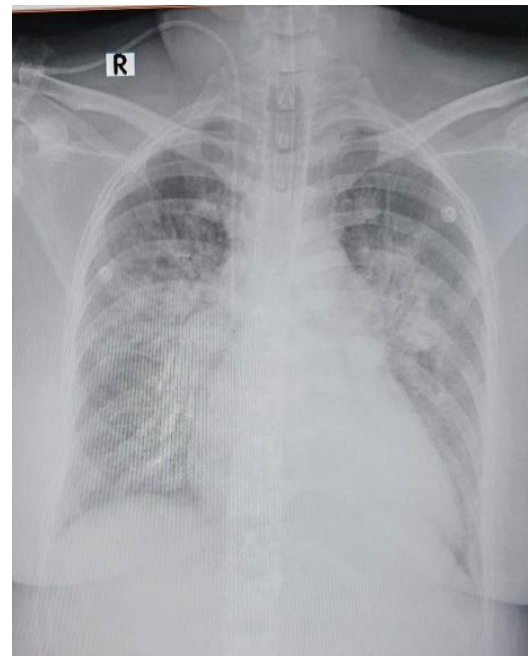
Chest X-ray Post Intubation
